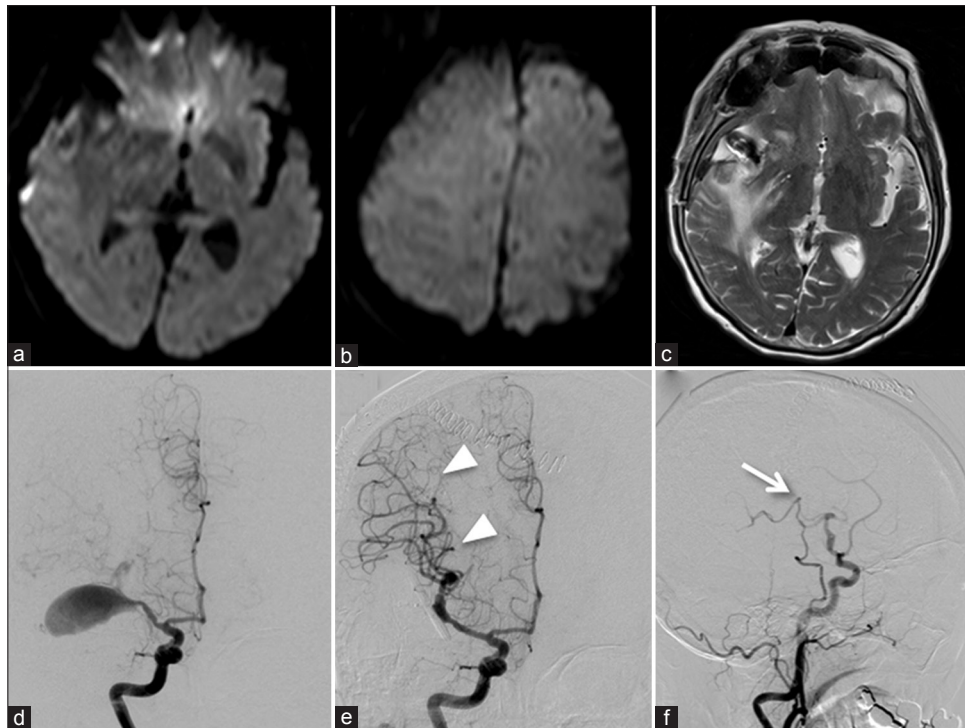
(a and b) Axial diffusion-weighted MR images obtained 1 day after surgery revealing no acute ischemia. (c) Axial T2-weighted MR image performed 1 day after surgery showing no new changes other than the preexisting edema around the aneurysm. (d) Preoperative angiogram demonstrating a giant MCA aneurysm. (e) Postoperative angiogram showing the complete obliteration of the aneurysm with preservation of the parent artery. Note the remarkable increase of the arterial flow in the MCA territory (arrowheads). (f) Right lateral carotid angiogram demonstrating that the bypass flow covered only a small area of the frontal lobe distal to the site of anastomosis (arrow)
